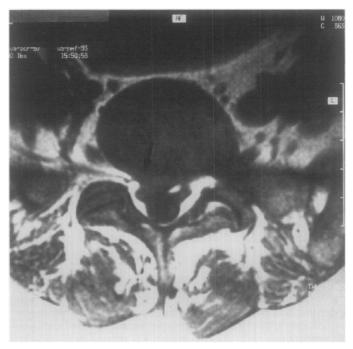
Axial T1-weighted MRI image of the lumbosacral spine with evidence of a large focal disk herniation at L5-S1 to the right with compromise of the S1 nerve root.
